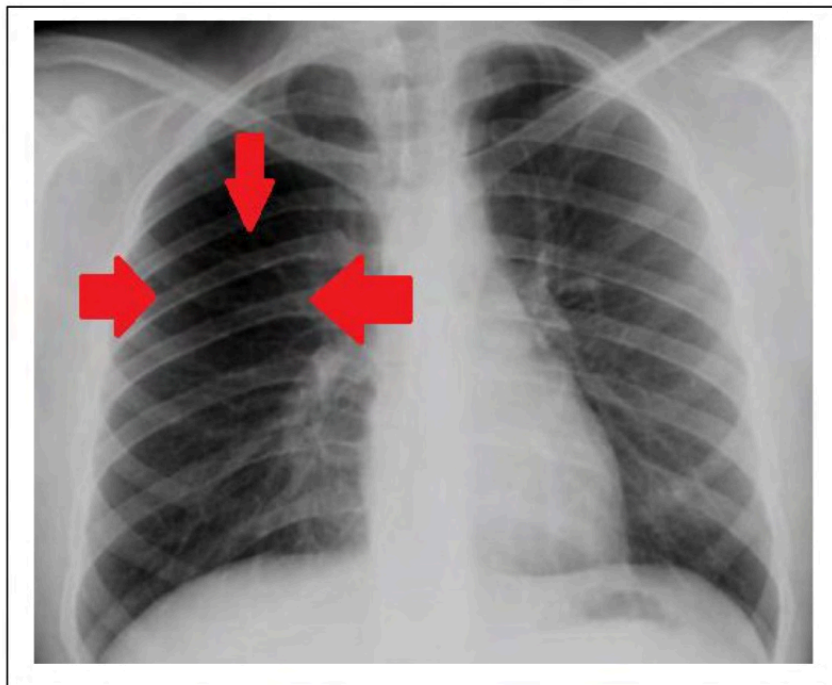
Chest X-ray: hypertransparency of the right hemithorax, due to the absence of the pectoral muscle.
